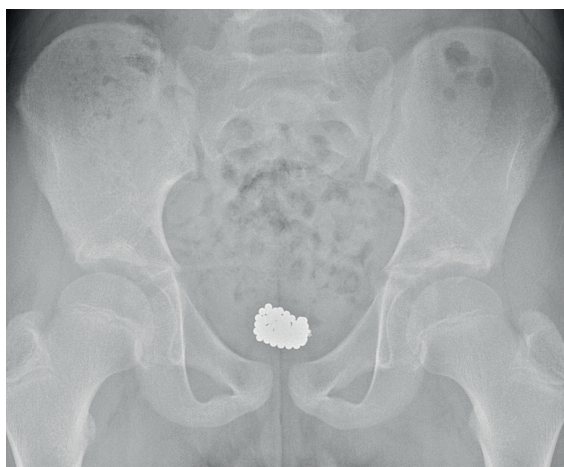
Image of Pelvic X-ray. Pelvic X-ray showed a metallic dense foreign body that was composed of many small balls in the pelvic region.
